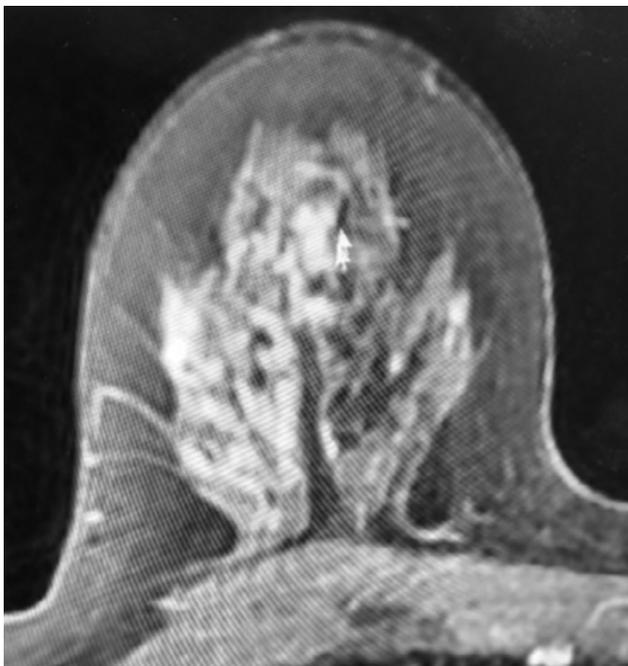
2017 right breast MRI upper outer quadrant.
